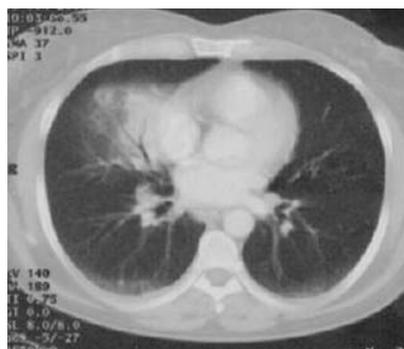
Computed tomography of the chest showing alveolar infiltration in the median lobe and mediastinal lymphadenopathy.
